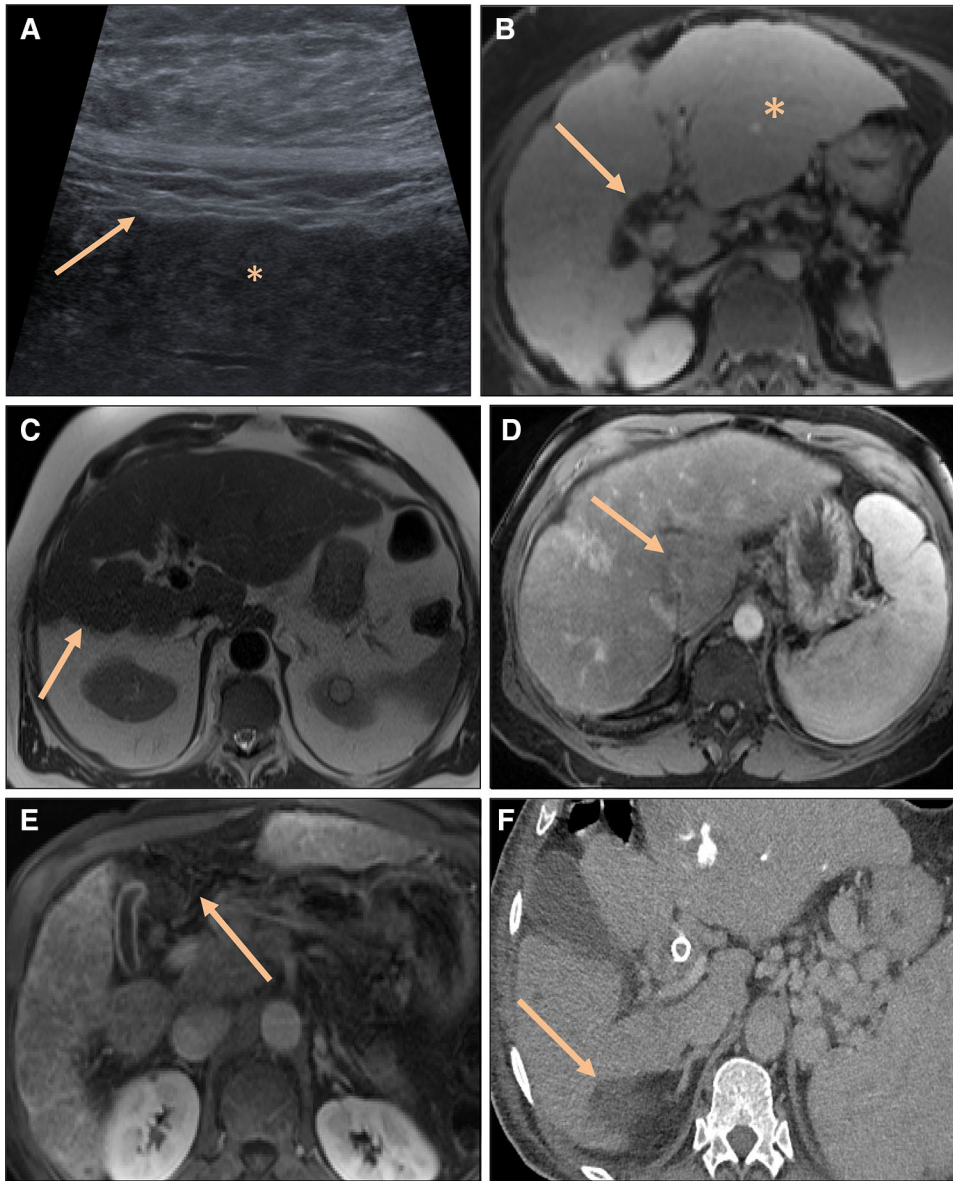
A–F Morphologic imaging features of cirrhosis in 6 patients. (A) Ultrasound shows a nodular surface (arrow) and coarsened echotexture (asterisk). MRI images of cirrhotic livers show (B) a nodular surface contour, hypertrophy of lateral left lobe (asterisk), and expanded hilar periportal space (arrow) on post-contrast T1 FS sequence, (C) atrophic right hepatic lobe (arrow) on axial T2 Half-Fourier Acquisition Single-Shot Turbo Spin-Echo (HASTE) sequence, (D) hypertrophy of caudate lobe on post-contrast T1 FS sequence (arrow), (E) expanded gallbladder fossa and atrophic medial segment left lobe on post-contrast T1 FS sequence (arrow). (F) Post-contrast CT in the portal venous phase shows a right hepatic posterior “notch” (arrow).
